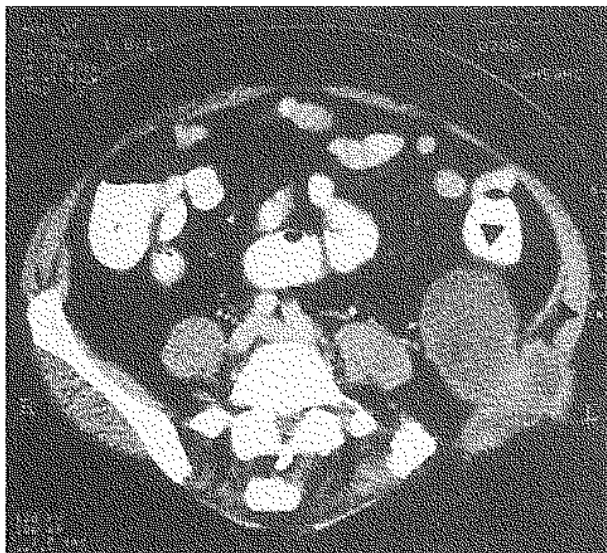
CT-scan revealed a large retroperitoneal tumor adjacent to the left iliac crest.
